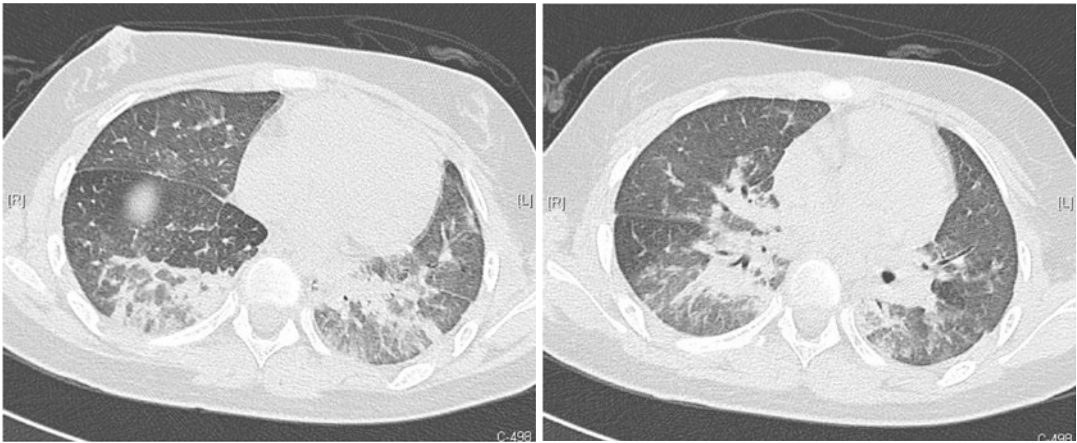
Chest computed tomography on hospital day 10 revealed multiple consolidation patches in bilateral upper and lower lobes without pleural effusion (Case 1)
